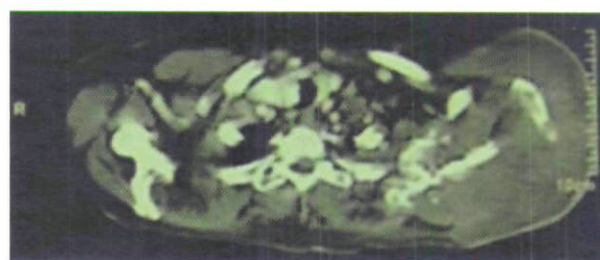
Computed tomographic scan showing the subcutaneous mass in correspondence of the shoulder involving the underlying bone structures with osseous destruction.
